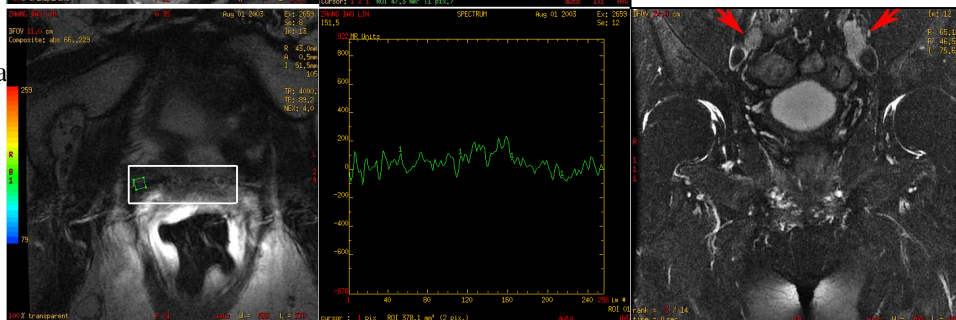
revealed metabolic atrophy of the nodule in the prostatic bed which indicated of absence local recurrence. MRI coronal T2WI demonstrated multiple lymph nodes metastasis along the pelvic vessels.
